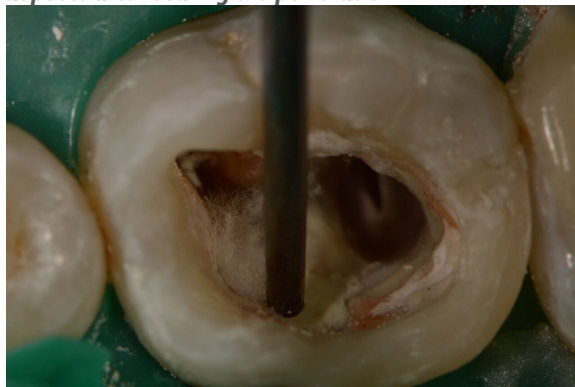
4B. Clinical (A) and radiographic (B) aspects after 6 months
